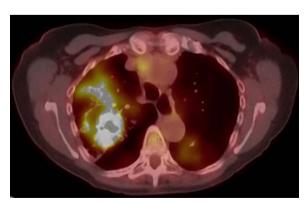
Positron emission tomography/CT scan showing standardised uptake value of 25.5 in right upper lung cavitary lesion.
